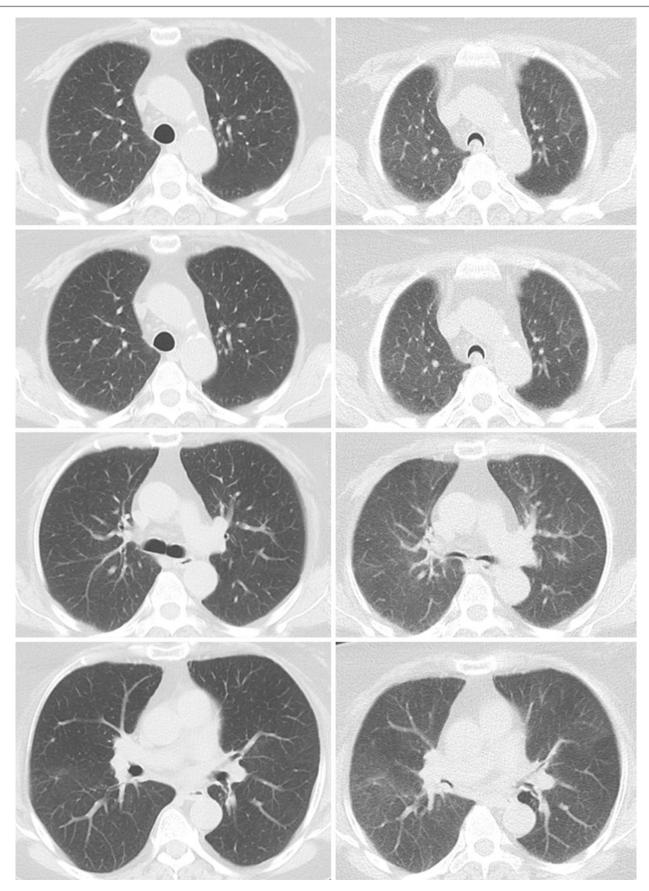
Tracheobronchomalacia in a 49-year-old woman, who was being treated for steroid-resistant asthma. Inspiratory and expiratory phase CT images at same position show marked collapsibility of the tracheobronchial tree. Note the "Frown sign"
